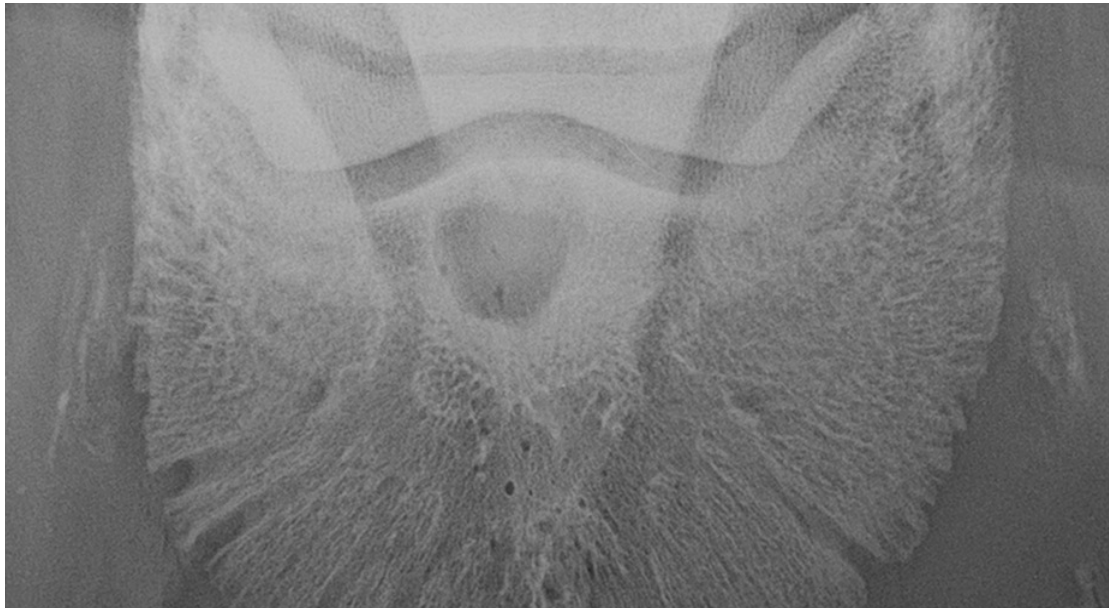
Dorsal 60° proximal - palmarodistal oblique radiographic view showing an SCL in the right front P3 in an eight-year-old gelding with chronic intermittent lameness. The SCL is located proximally and sagittally and has a suspected neck-like communication with the distal interphalangeal joint.
